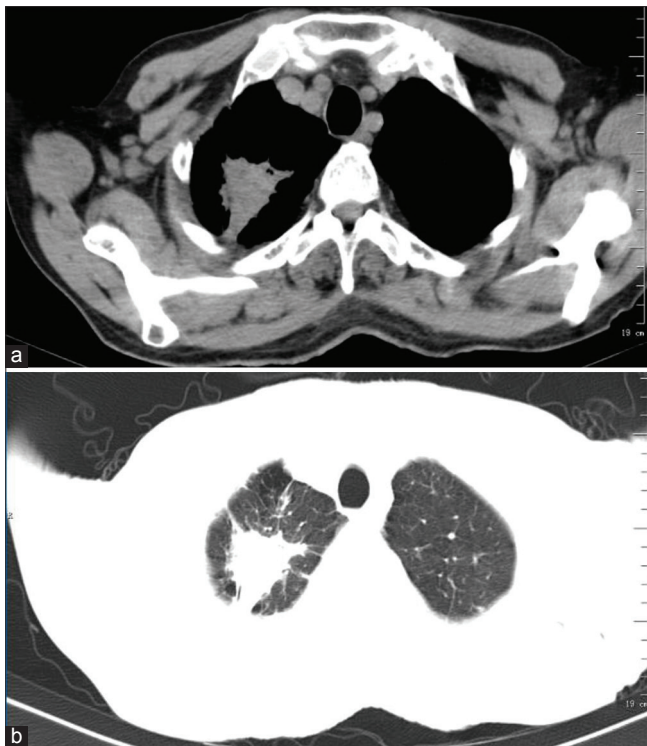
Abdominal pain as initial presentation of lung adenocarcinoma (a, b) CT image of lung neoplasm
